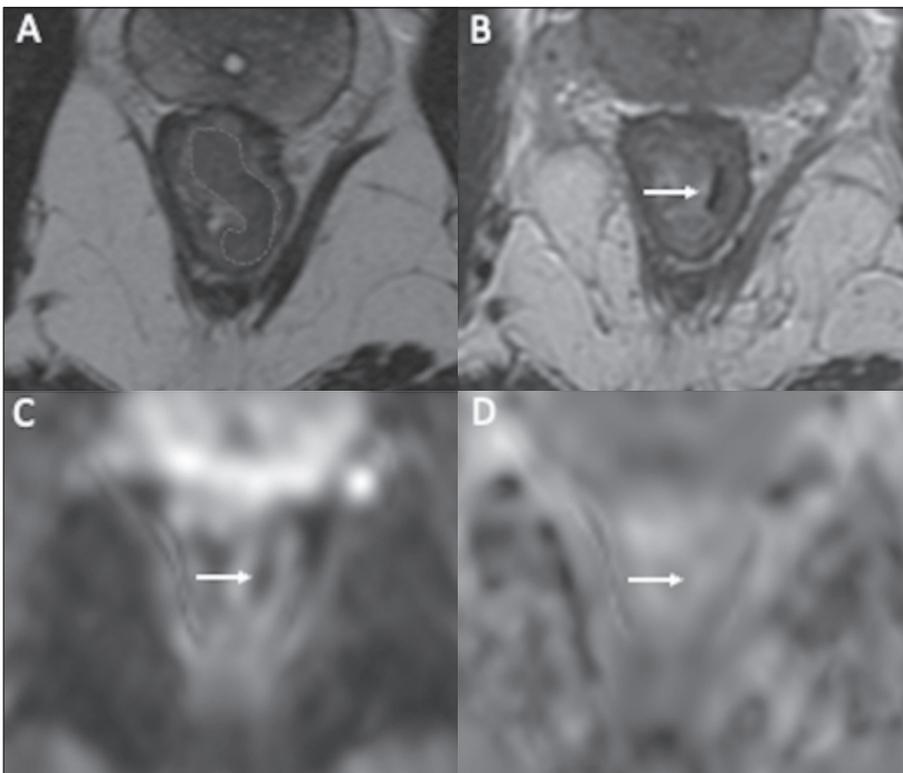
A cCR after NAT in a 41-year-old man with low-rectal adenocarcinoma. A: Baseline axial T2WI showing a low-rectal tumor (dotted line). B: Axial T2WI after the completion of NAT shows a thin hypointense scar at the site of the treated tumor (arrow). No diffusion restriction was present on DWI (C) or ADC mapping (D).
